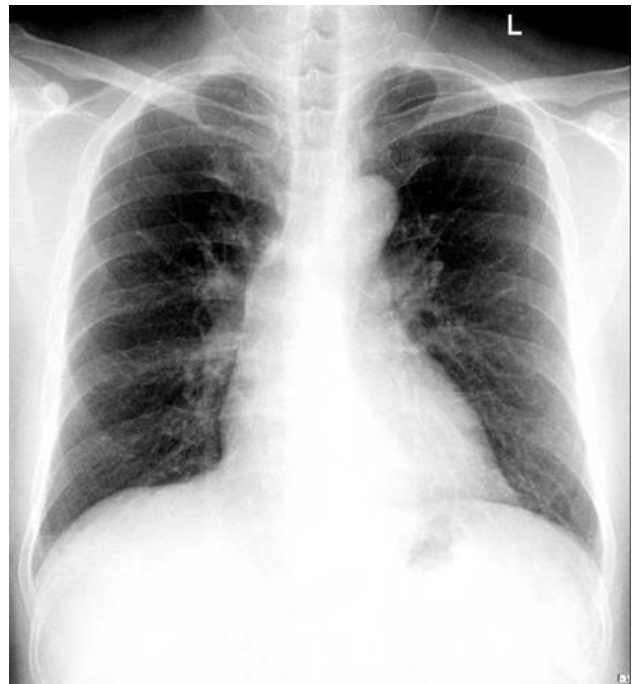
Chest X-ray showed aorta sclerosis, with CTR
